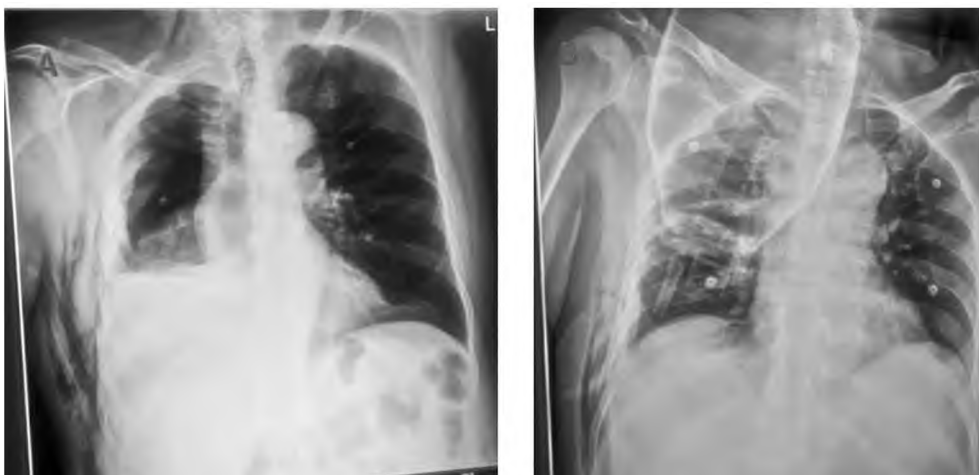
Chest X-ray of case of delayed hemothorax managed by intercostal drain.
